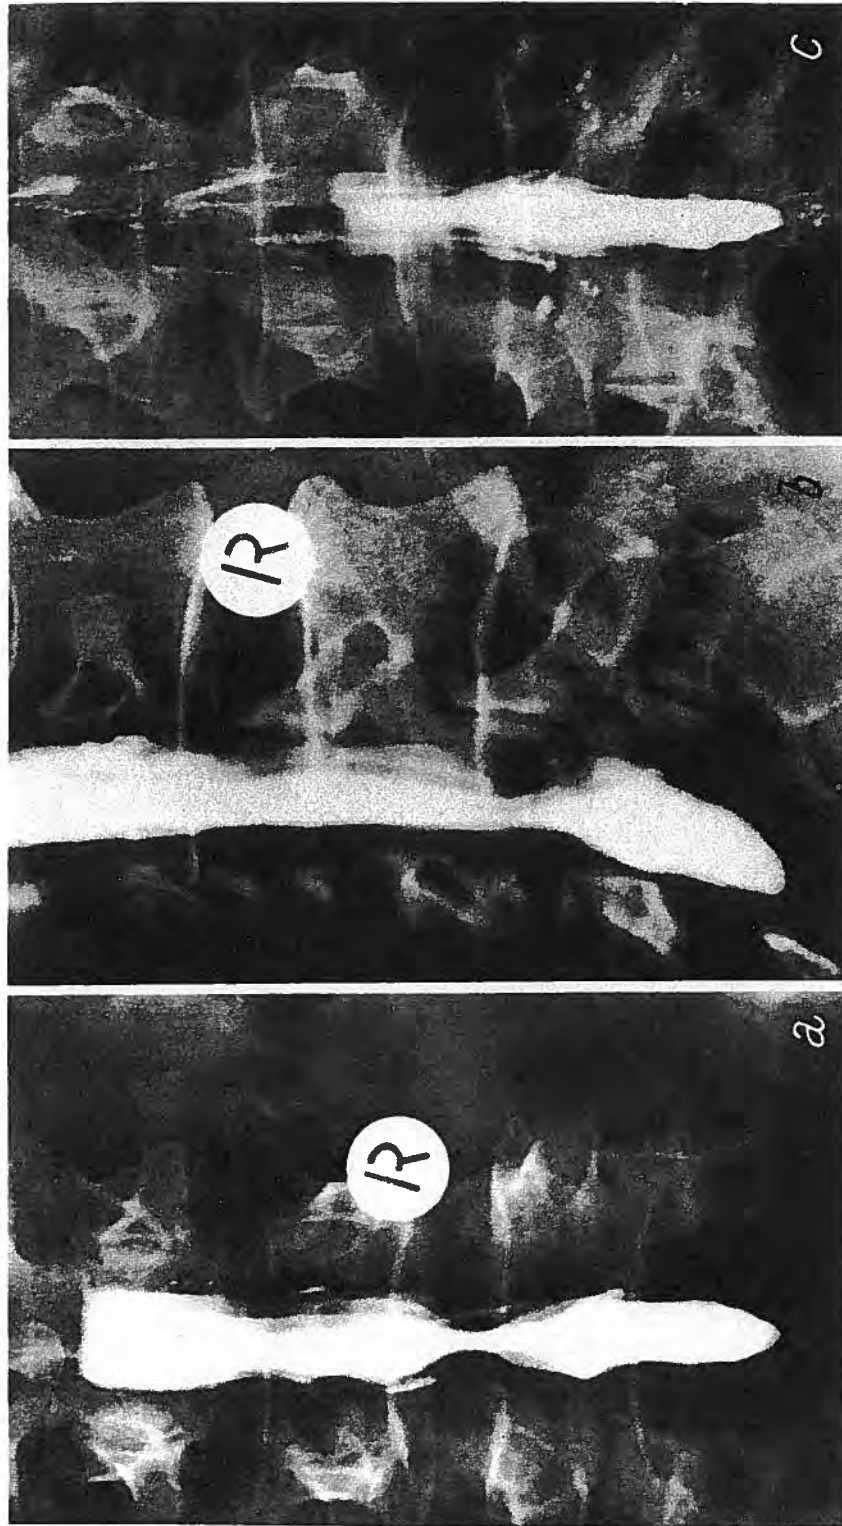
c A lateral radiograph of the same spine showing the myelogram with complete blockage of the flow of myelogram at the distal border of L3 and a stenotic lesion at L2/3. At operation, the cause of this stenosis was due in part to secondary degenerative changes in the roofing structures of the spinal canal at L2/3 and L3/4, but the main cause of the complete obstruction at L3/4 was massive disc sequestration. d An antero-posterior radiograph of the same spine taken six months after operation in which multi-level canal decompression was carried out, together with excision of the disc fragment and localized interbody fusion at L3/4
